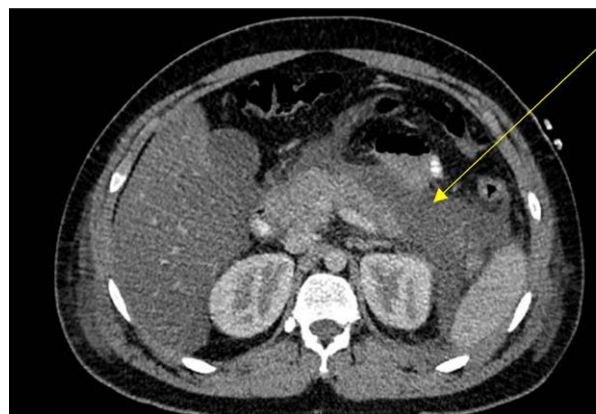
CT scan findings 2 days later demonstrating peripancreatic edema, fat stranding, peripancreatic fluid collection medial to spleen. Arrow demonstrating acute peripancreatic fluid collection.
